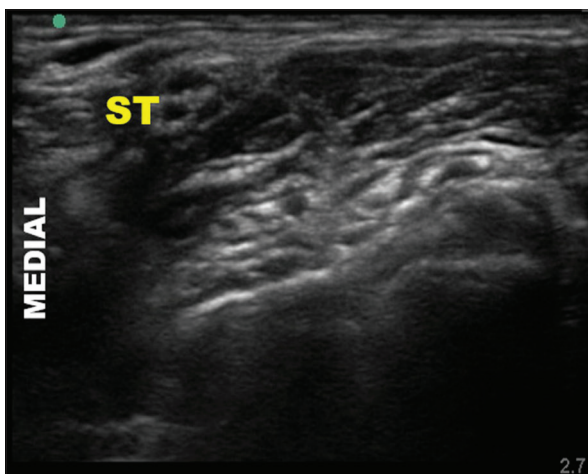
Ultrasonographic image of the superior trunk after local anesthetic injection; ST, superior trunk
